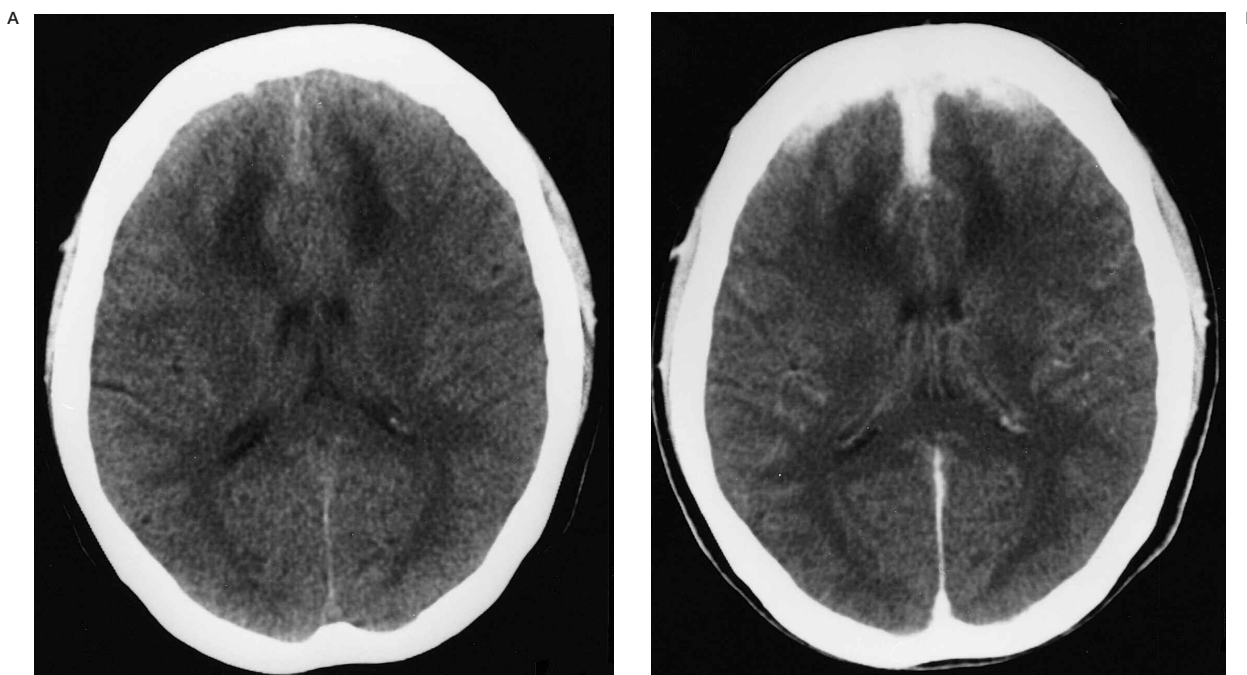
Plain (A) and enhanced (B) computed tomography (CT) scans showing a tumor limited to the cranium and dura.
